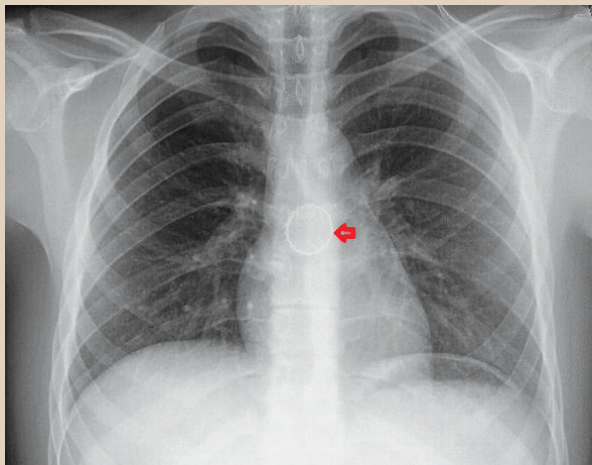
Chest radiography revealing the bottle cap as a circular radio-opaque shadow with a peripherally serrated rim.
